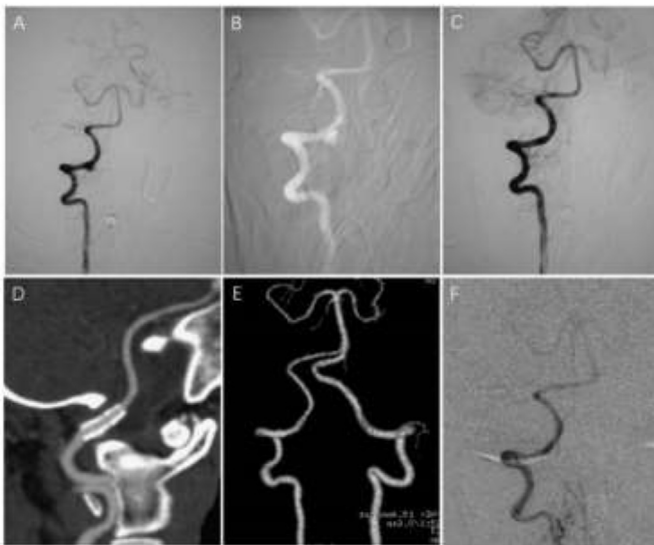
A 55-year-old female suffered with repeated dizziness in recent 5 years. A, a nodominant right VA angiogram revealed a hemispherical dissecting aneurysm in the V3 segment; B, under the roadmap, Willis covered stent ($3.5 \times 10\text{mm}$) was implanted; C, immediate angiograms post EVT demonstrated the complete occlusion of the VADA; D and E, CTA of the one month follow-up demonstrated the stable occlusion of the VADA and patency of VA without any stenosis; F, the 24 months follow-up angiograms demonstrated the complete occlusion of the VADA without in-stent stenosis.
